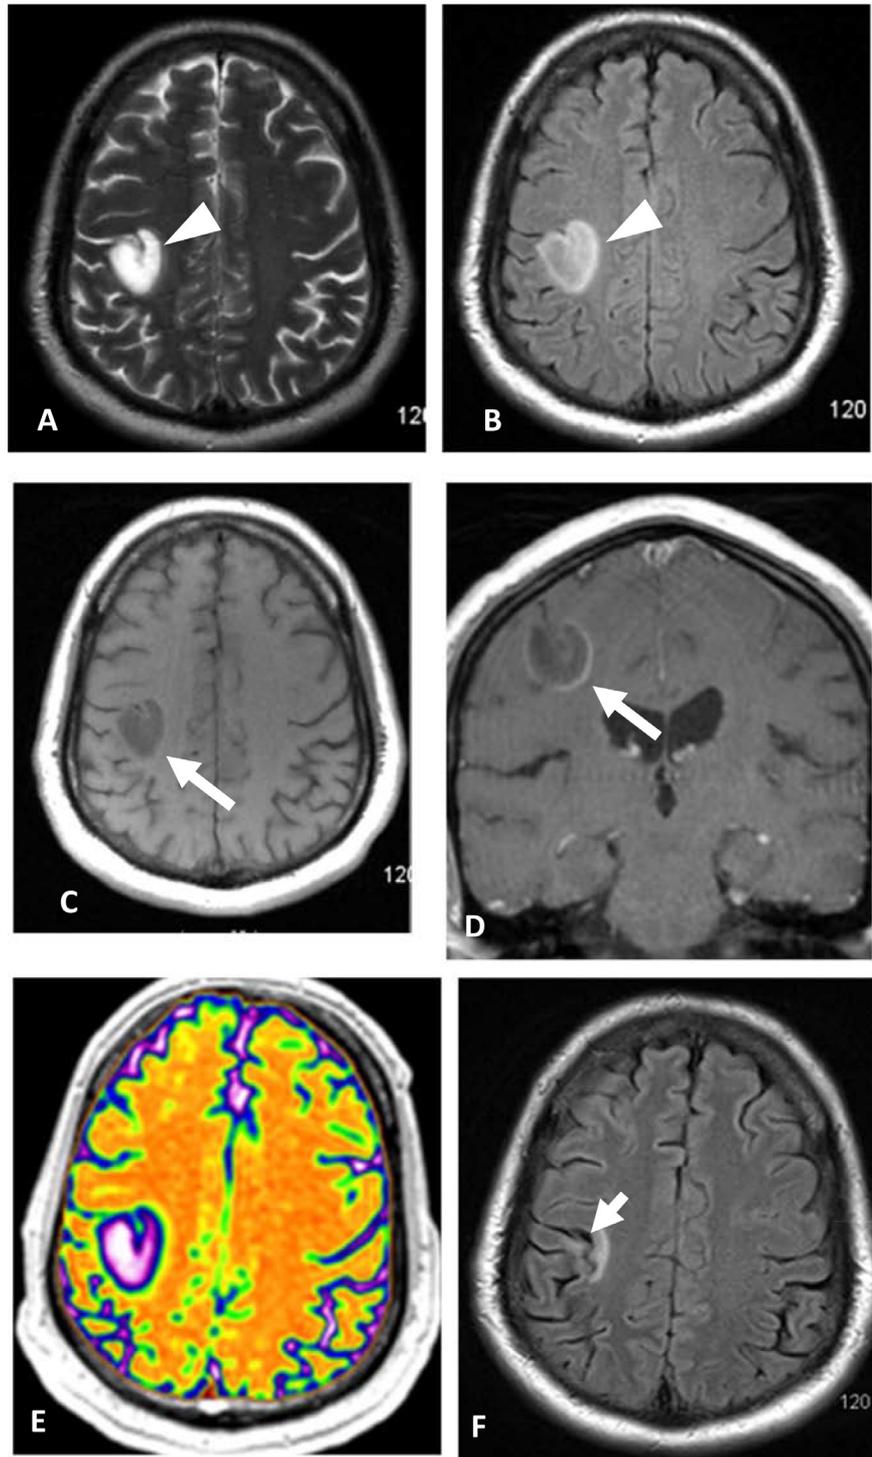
(Case 3): Axial T2W (A) and FLAIR (B) MRI images show a well-defined hyperintense lesion with a concentric pattern in the right perirolandic region (arrowheads). Axial pre-contrast (C) and coronal post-Gd (D) T1W MRI images of the brain show incomplete peripheral enhancement (long arrows in C and D). Axial mean diffusivity maps (E) show centrifugal pattern of diffusivity in the right perirolandic lesion with maximum diffusivity seen centrally. Three-year follow-up axial FLAIR MRI (F) shows significant resolution of the right perirolandic lesion (small arrow). No interval lesions were found.
